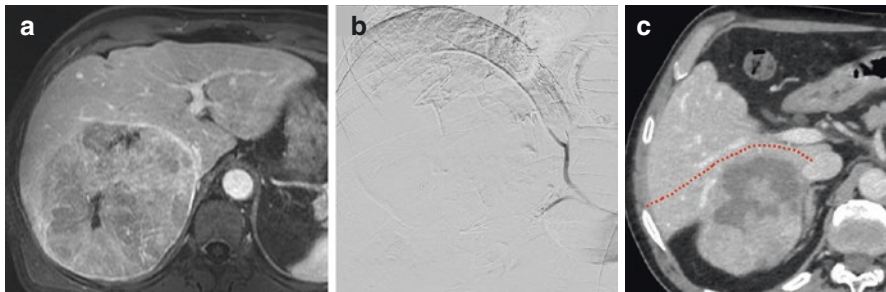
Seventy-year-old male. (a) CT scan: large right lobe hepatocellular carcinoma. (b) Selective transarterial chemoembolization (TACE). (c) CT scan after TACE: tumor shrinkage and partial necrosis. Indication for right posterior sectionectomy (S6–S7)
